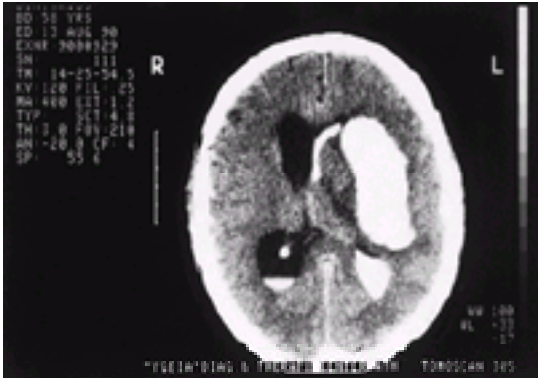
CT scan showing a large primary intracerebral bleed in a 58-year-old hypertensive man. This haematoma has ruptured into the ventricle and blood can be seen layered in the right occipital horn. There is secondary hydrocephalus due to shift of the midline structures preventing egress of cerebrospinal fluid from the right lateral ventricle.
